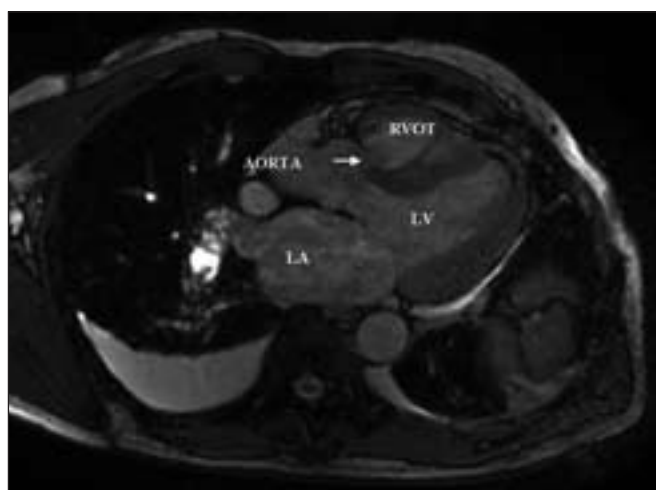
Cardiac magnetic resonance imaging shows a ruptured right coronary sinus of Valsalva into the right ventricle. Arrow shows the ruptured sinus of Valsalva. RVOT=right ventricular outflow tract, LV=left ventricle, LA=left atrium.
